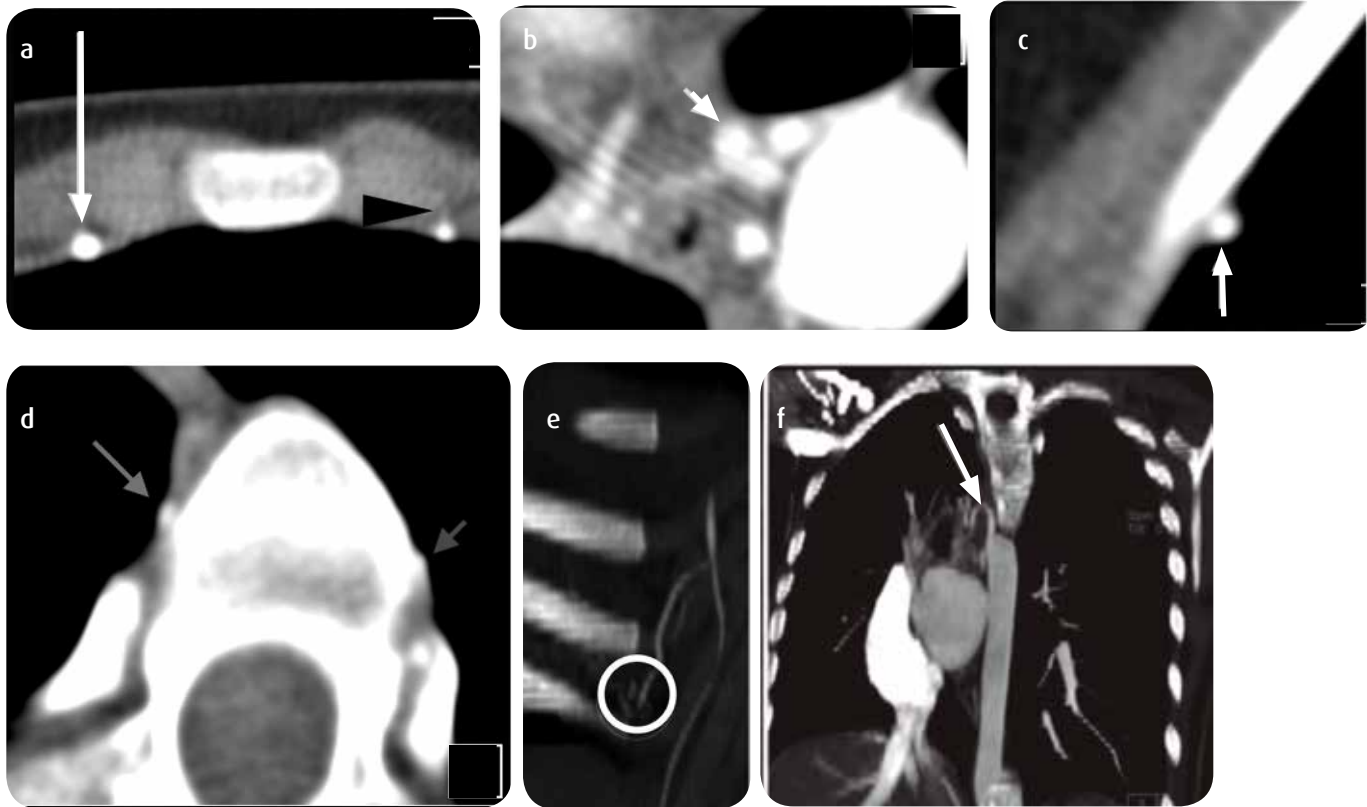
Angio CT of the thorax, vascular structures that irrigate the right lung: a) Asymmetry in the internal mammary arteries (arrow); right internal mammary (arrowhead); left internal mammary, with increase in the size of the right internal mammary, measured 3.5 mm compared to the left internal mammary artery, 1.5 mm. b) Dilated right bronchial arteries (arrow). c) Dilated intercostal artery in the right hemithorax (arrow). d) Intercostal arteries in the proximal segment, asymmetry in the size of the right intercostal artery (long arrow) compared to the left intercostal artery (short arrow). e) Coronal MRI, branches of the internal mammary artery that perfuse the middle and lower lobe of the right hemithorax (circle). f) Coronal MRI, origin and vascular weave of bronchial branches that perfuse the upper lobe of the right hemithorax (arrow).
